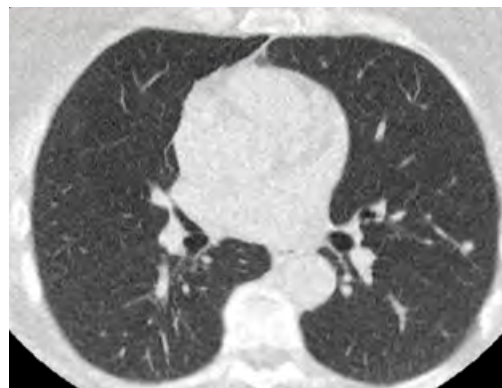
an ultralow-dose 3-mm axial chest CT of the same patient acquired on a 320-detector-row scanner (Aquilion ONE) and reconstructed with AIDR 3D shows a 7-mm nodule.
